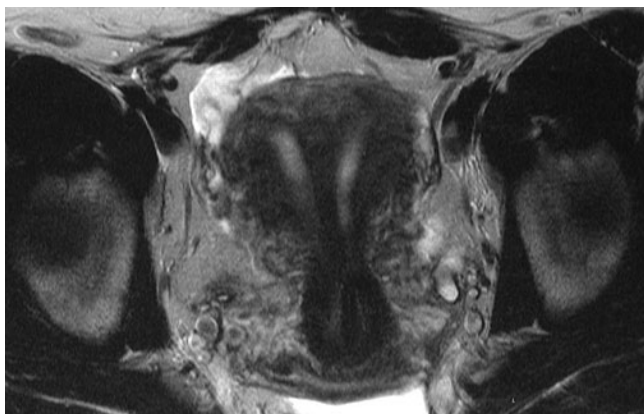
Müllerian duct anomalies (MDA): septate uterus. T2-weighted magnetic resonance image (MRI) obtained in the true coronal plane of the uterus shows two symmetric uterine horns and cervixes, with an intervening septum consistent with a complete, septate uterus. Note the straight fundal contour
